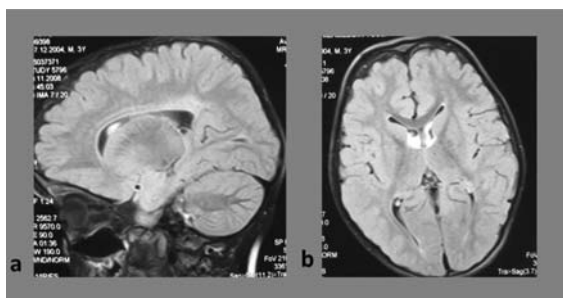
At age 4, brain MR imaging showed megalencephaly, a. corpus callosum dysgenesis and b. ventricular dilatation.
